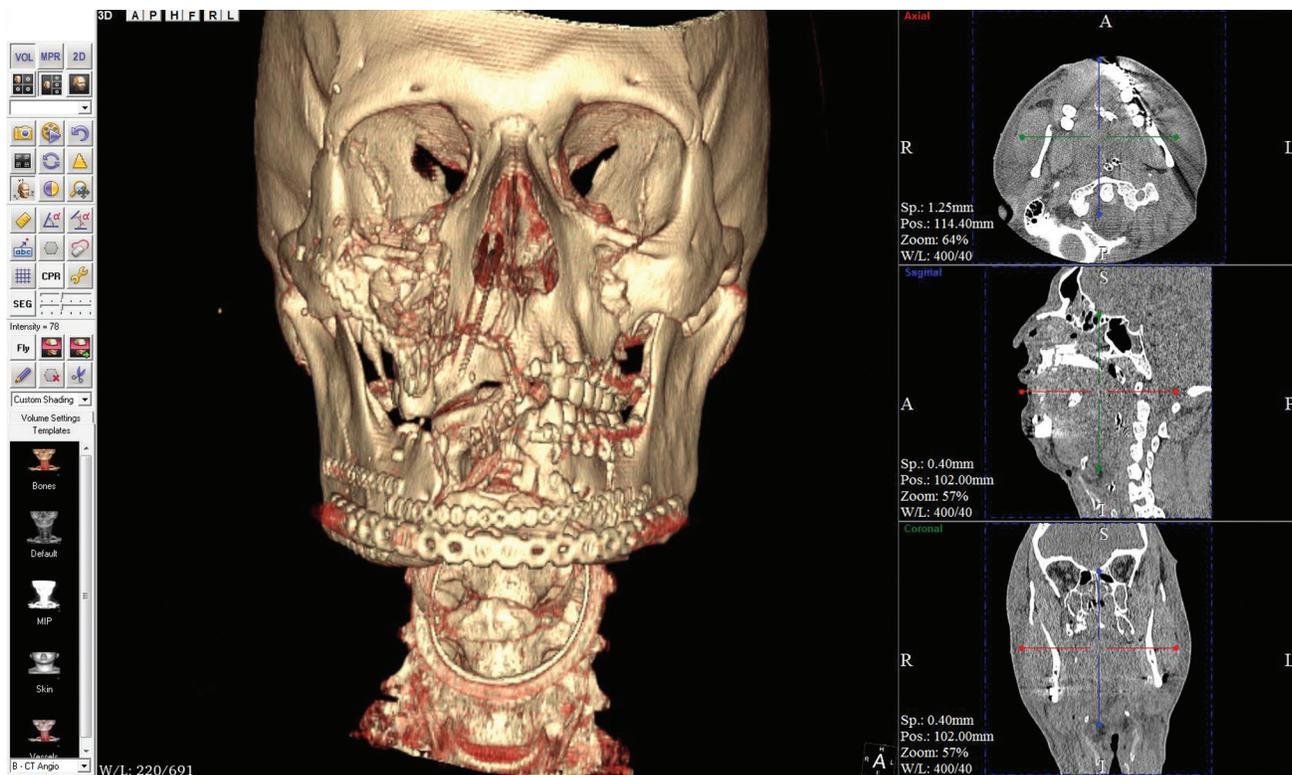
(b). Postoperative computed tomography scan.
